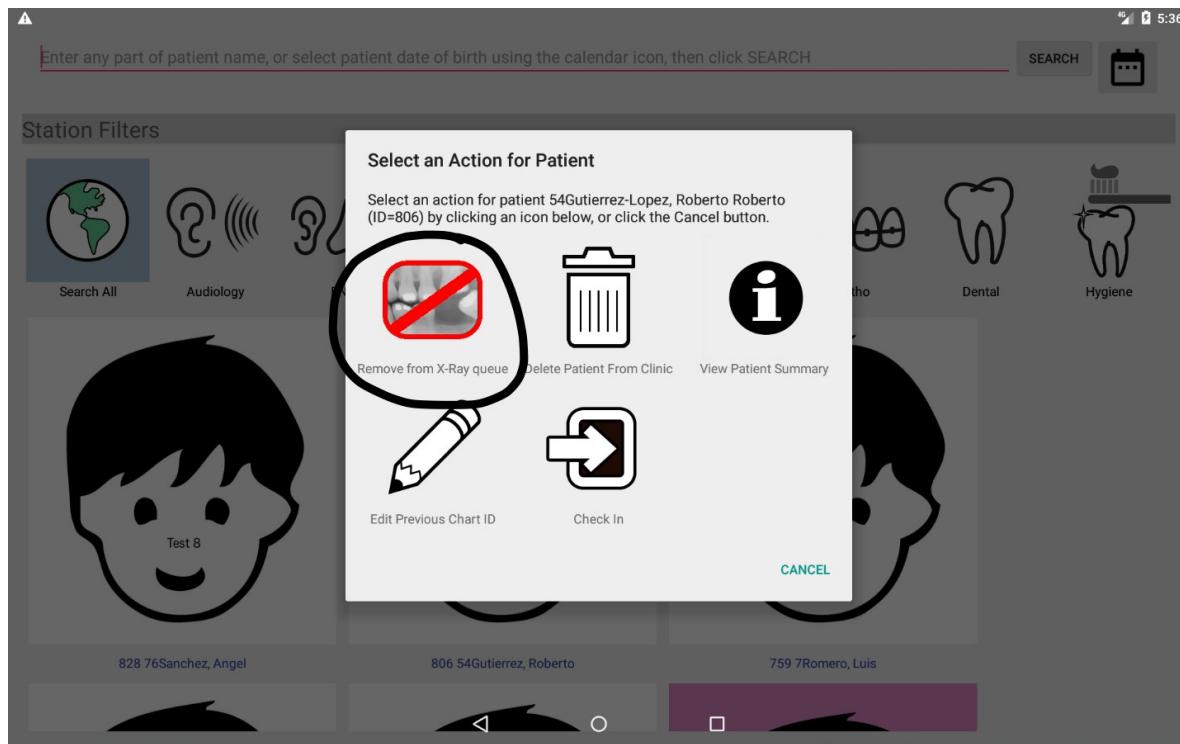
Patient with Recent X-Rays showing button for removing x-ray from routing slip
